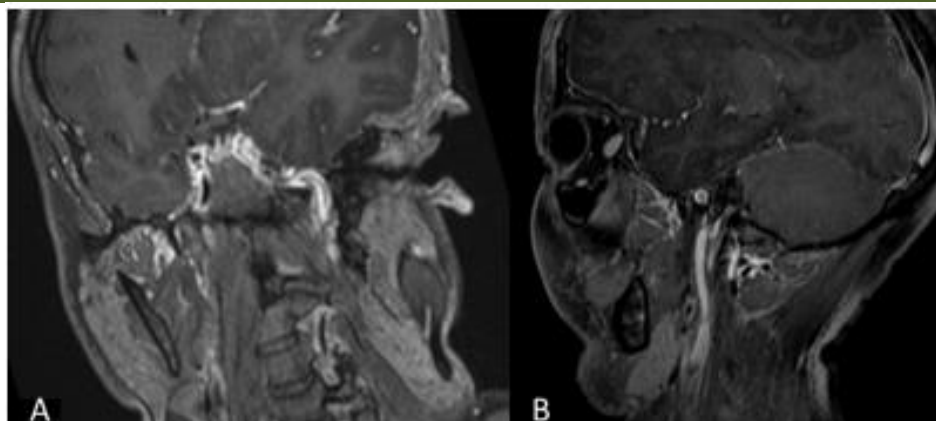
Brain MRI coronal (A) and sagittal (B): T1 FAT SAT sequences after gadolinium injection showing an intimal flap of the right internal carotid artery (ICA)
